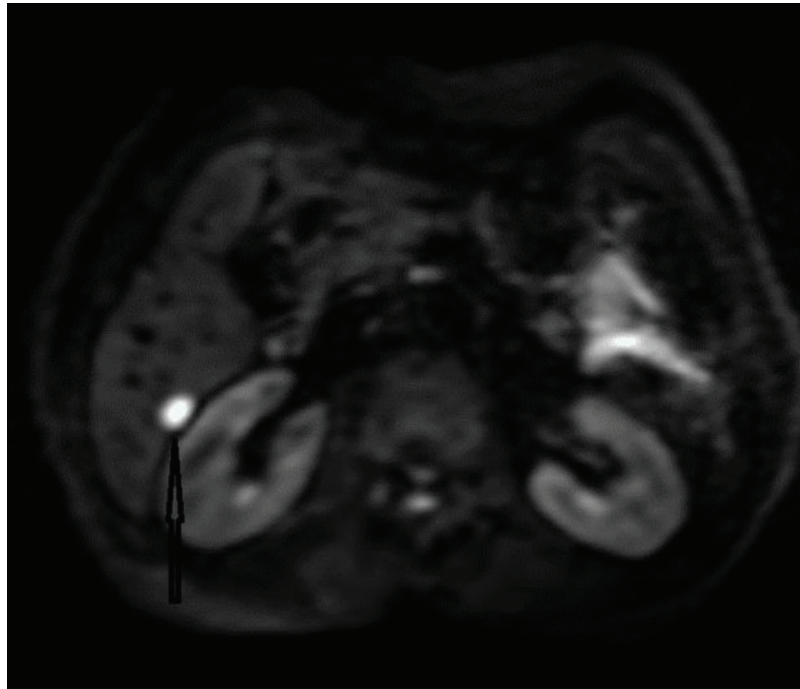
The abdominal MRI. Hyperintense lesion in segment 6 of the liver (arrow) on diffusion-weighted imaging – progression.
